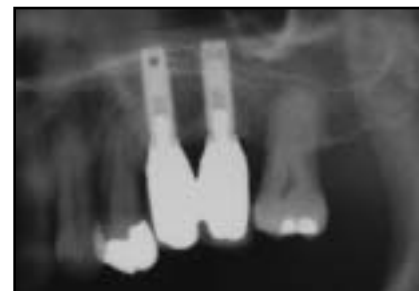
(right) Orthopantomogram after 7 years of prosthetic loading. Peri-implant regenerated bone at left second premolar and first molar sites and bone level of first premolar are radiographically stable.
